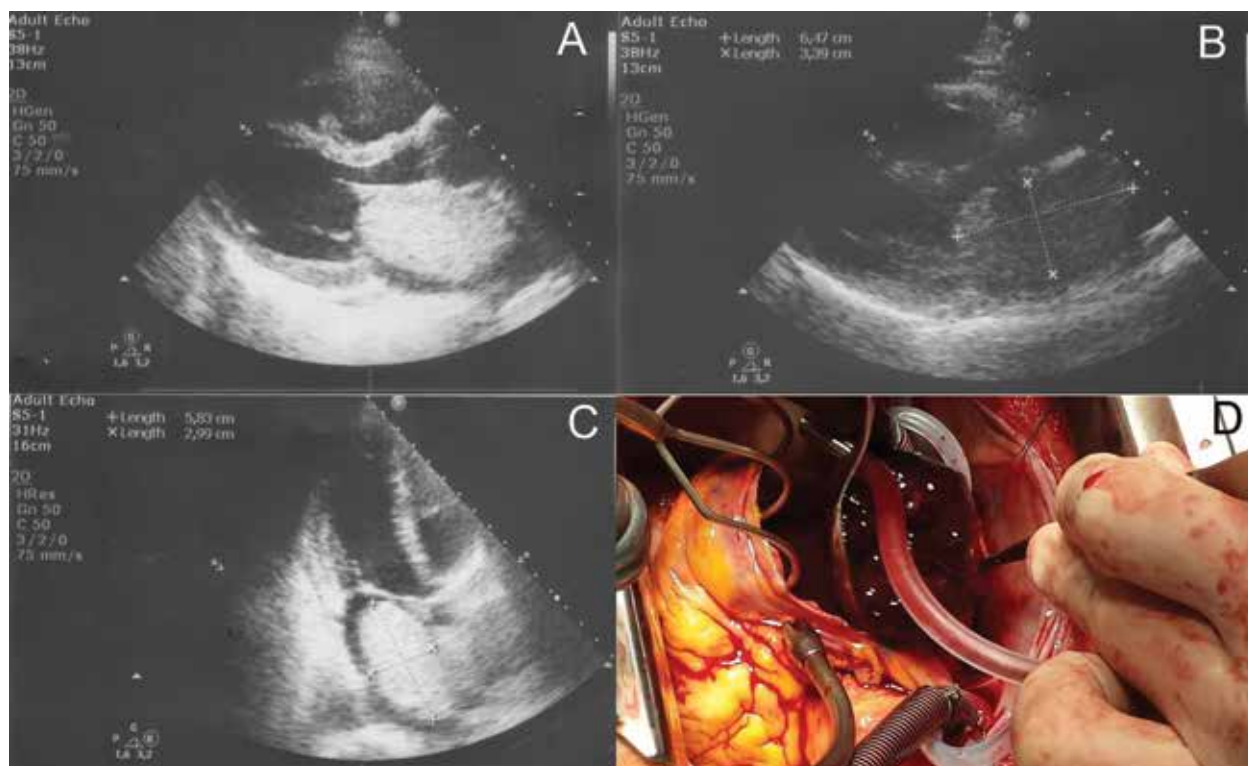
Parasternal long axis echocardiographic view demonstrated tumour mass in left atrium; B, C. Apical four chamber echocardiographic view of tumour; D. Tumour during cardiac surgery
